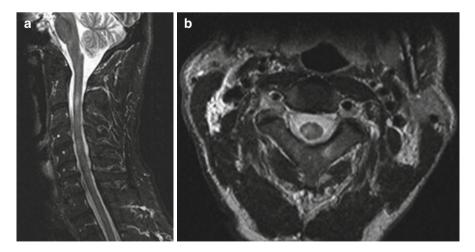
(a, b) Multiple cervical lesions noted on MRI spine consistent with multiple sclerosis
